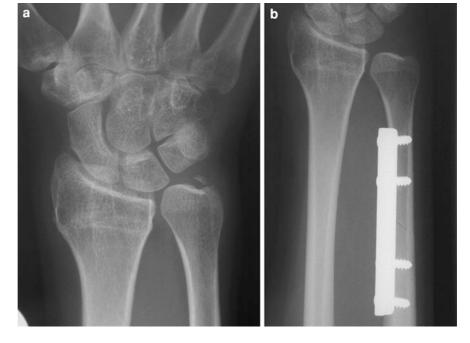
PA and lateral radiographs (a) of a young adult with malunion of a distal radial fracture with residual dorsal angulation. There is also non-union of the ulnar styloid, and the DRUJ was clinically unstable. The post-operative
